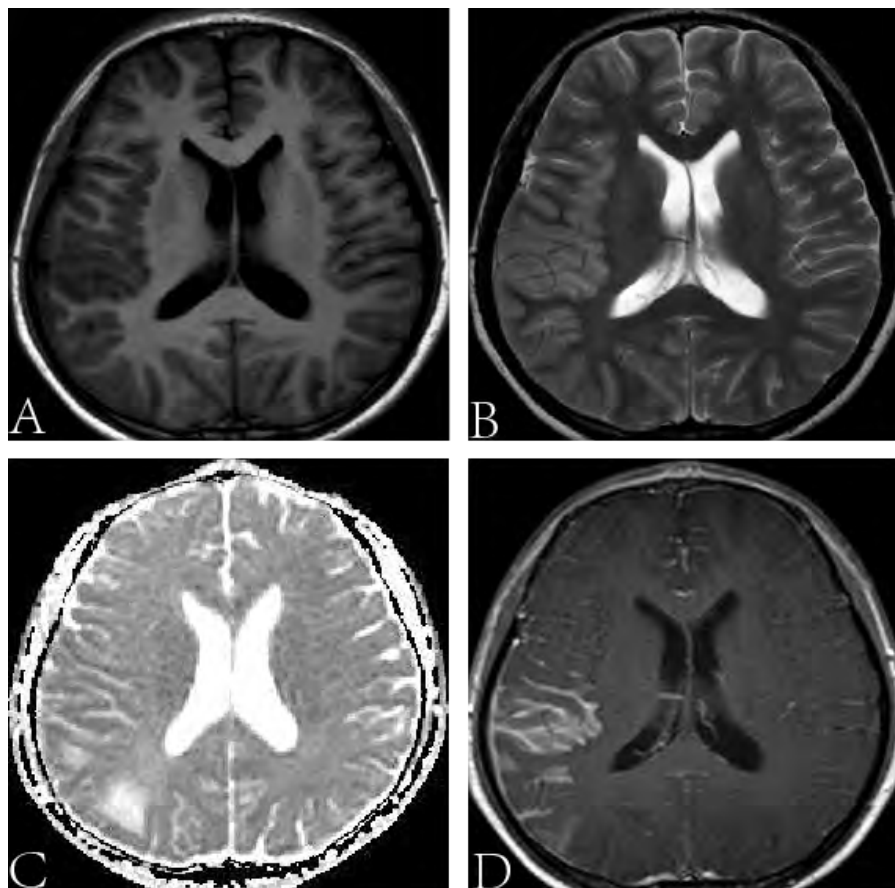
The gadolinium enhanced cranial MRI. There were lesions in the right parietal temporal cortex, it was low density in T1W1 (A), high density in T2W2 (B), high density in DWI (C), and enhanced in T1W1-weighted imaging (D).
